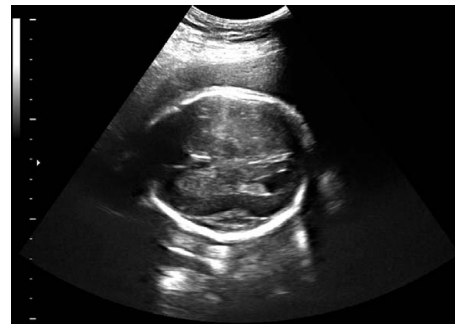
Prenatal ultrasound at 31 weeks' gestation showing ventriculomegaly and abnormal sulcal development with absence of gyri and sulci, and a shallow Sylvian fissure.
